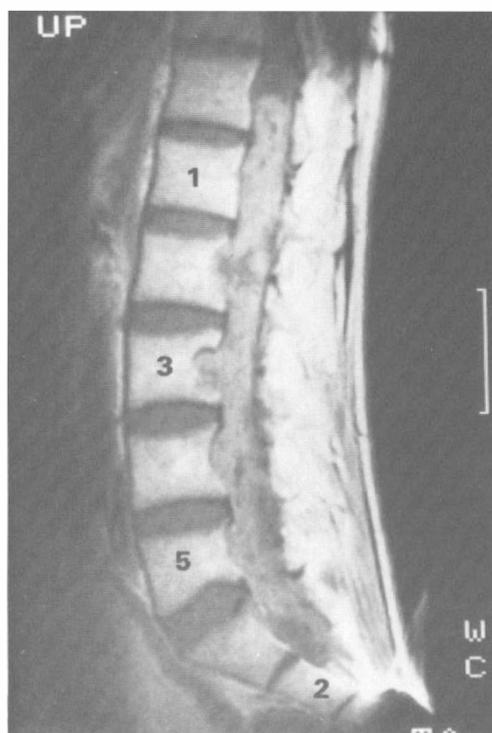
Case 6, myxopapillary ependymoma. T1-weighted MR images with Gd-DTPA enhancement showing a large tumour from T12 down to S2 with erosion of the vertebral bodies. This is the second largest in this series.
